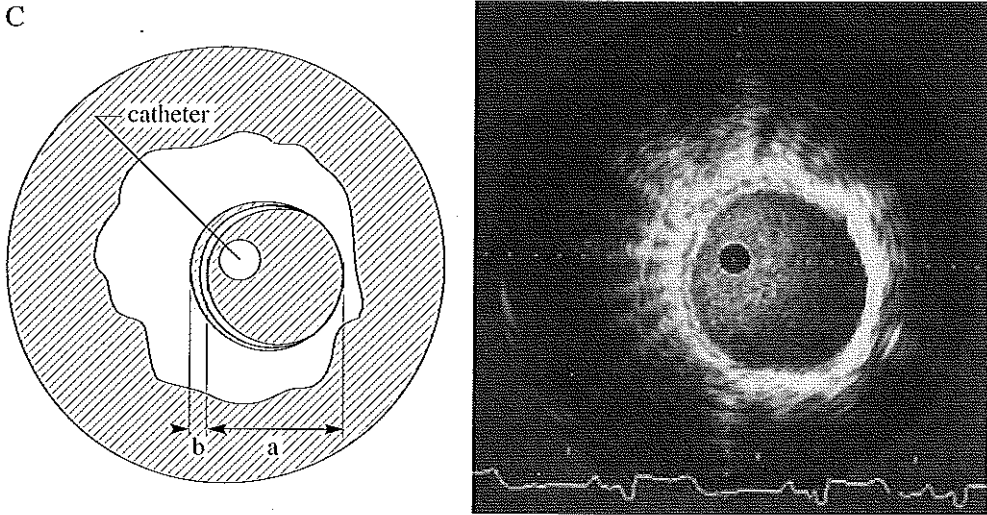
Pulmonary arterial wall characteristics as defined by intravascular ultrasound.
